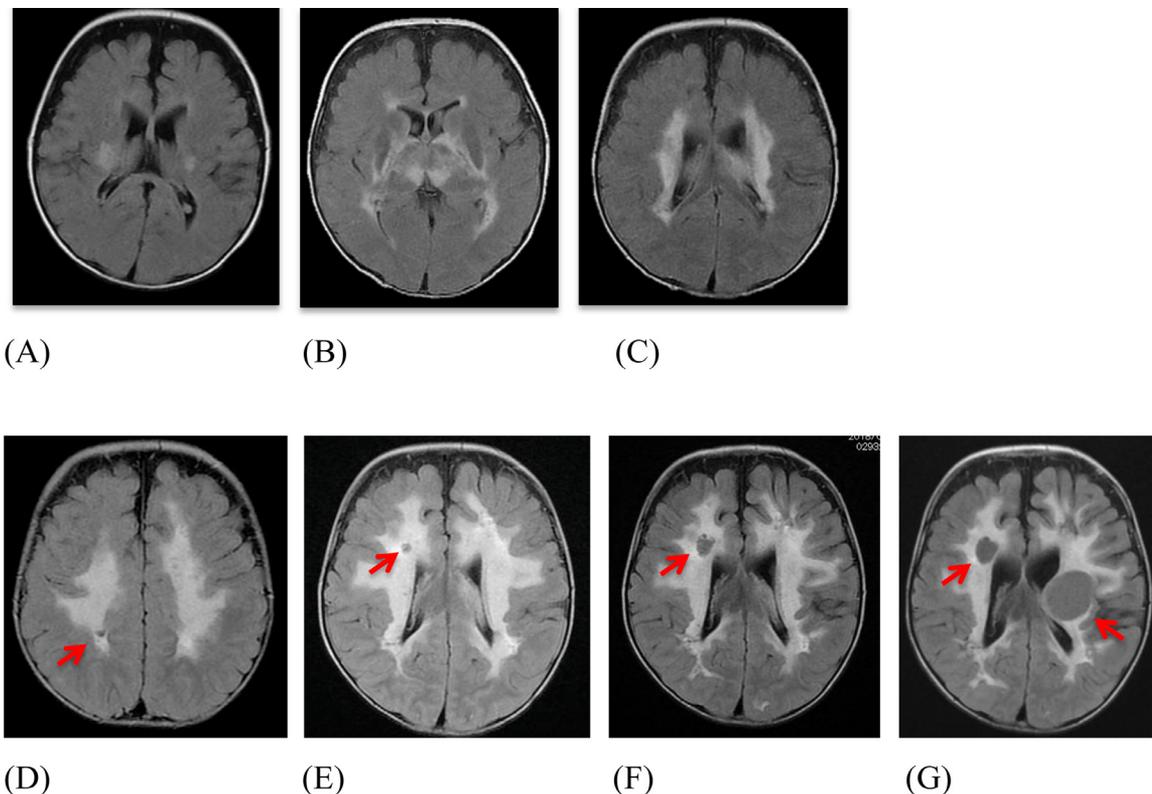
Axial magnetic resonance imaging FLAIR showed hyperintense lesions in the white matter on T2-weighted and FLAIR images at 7 months (A) and expanded diffusely at 11 months (B,C). Small cysts appeared inside the white matter lesions at 1 year and 6 months (D; red arrow) and 2 years and 7 months (E; red arrow). Cystic lesions increased bilaterally and became enlarged rapidly at 3 years and 7 months (F; red arrow) and 4 years and 8 months (G; red arrows).
